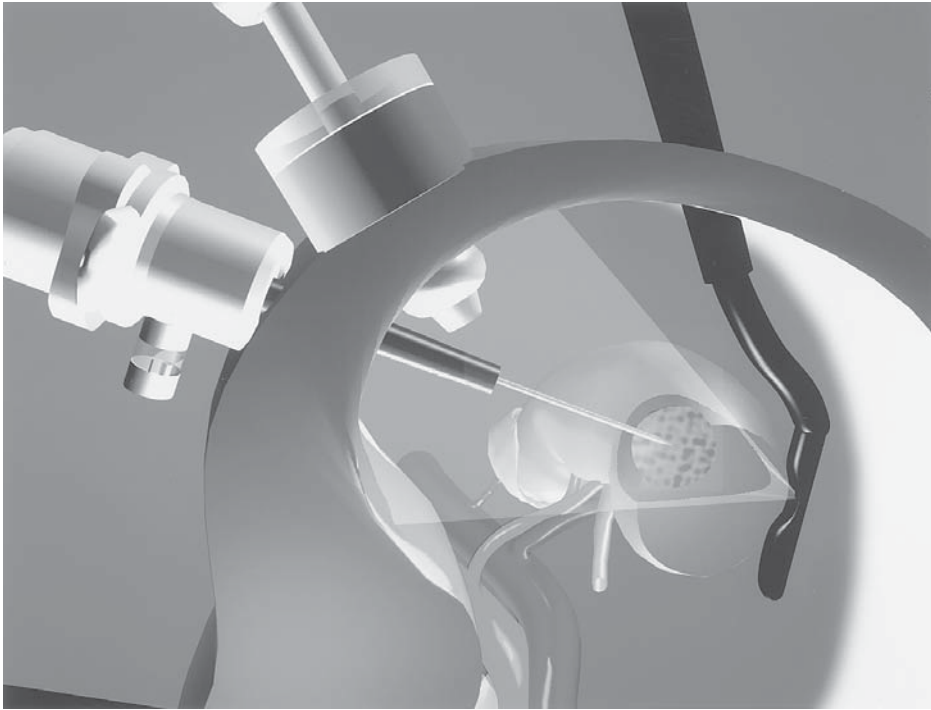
Needle biopsy of the renal tumor under laparoscopic visualization and ultrasound monitoring.
